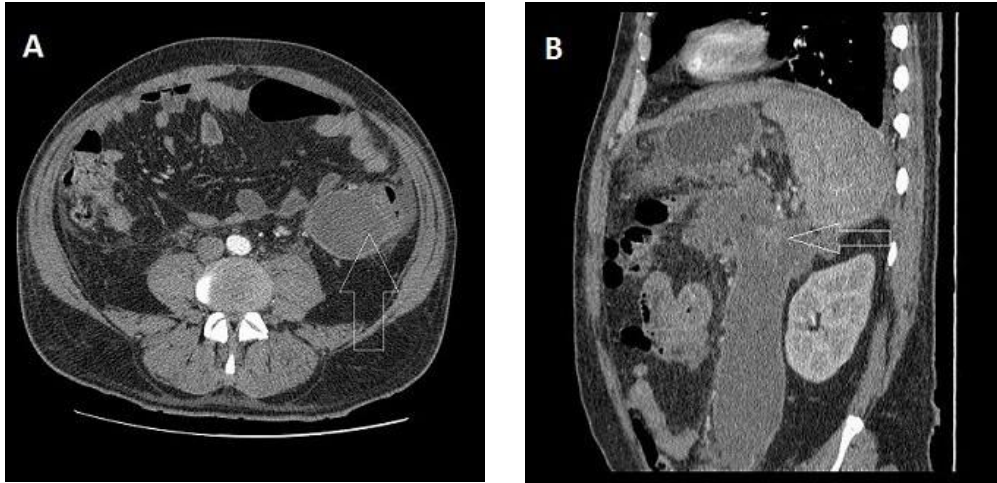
Contrast-enhanced axial CT section (A) and sagittal CT section (B) of the same patient with acute necrotizing pancreatitis, showing a well-defined (peri)pancreatic fluid collection in the left retroperitoneal space (arrows).
